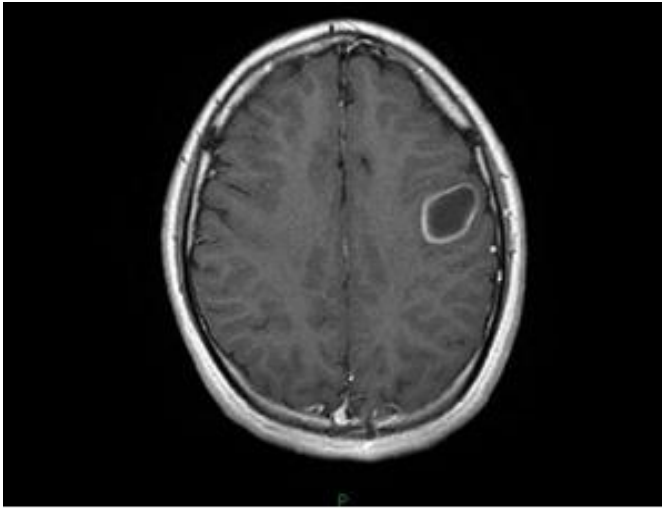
Pre-MR image with contrast.
